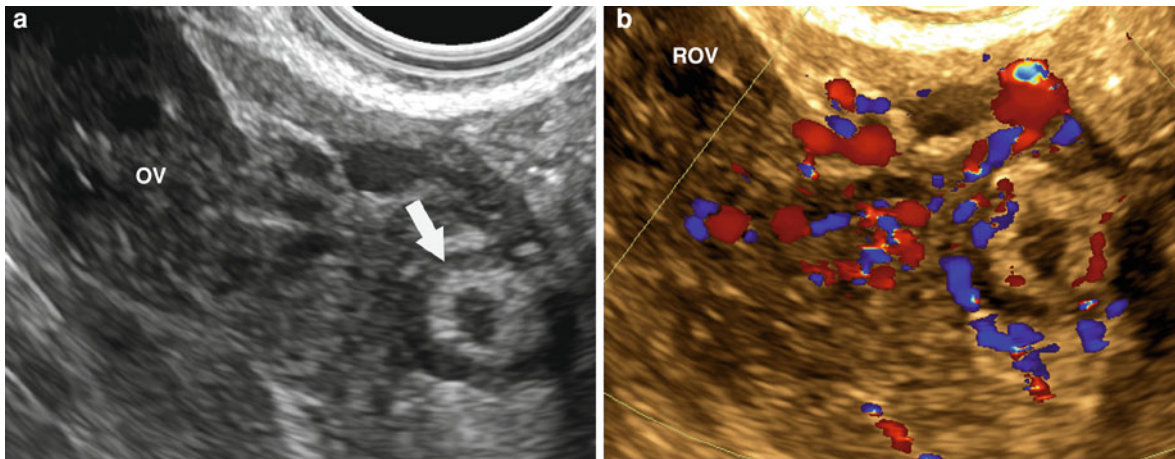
a, b Value of endovaginal probe for detection of pelvic appendicitis. Note identification of inflamed appendix in short axis (*white arrow*) adjacent to right ovary (“OV”) on grayscale endovaginal sonogram. In b, color Doppler endovaginal
